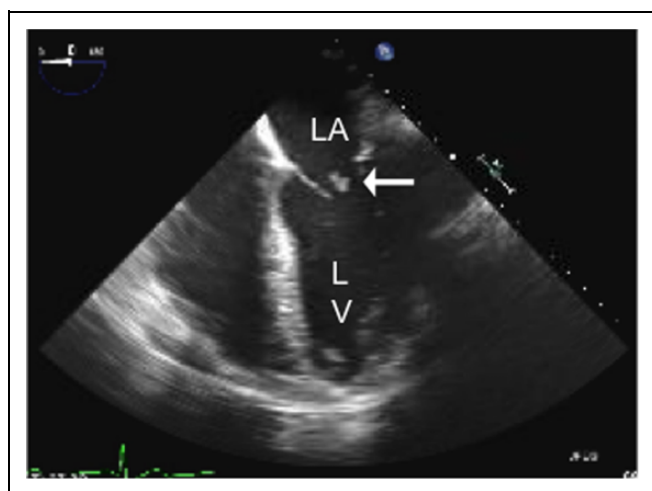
Transesophageal echocardiogram. Four chamber view of the heart showing the left atrium (LA), left ventricle (LV), and mitral valve demonstrating small mobile vegetations present on both leaflets of the mitral valve. Arrow points to the larger vegetation. The initial transthoracic echocardiogram did not reveal these vegetations.
